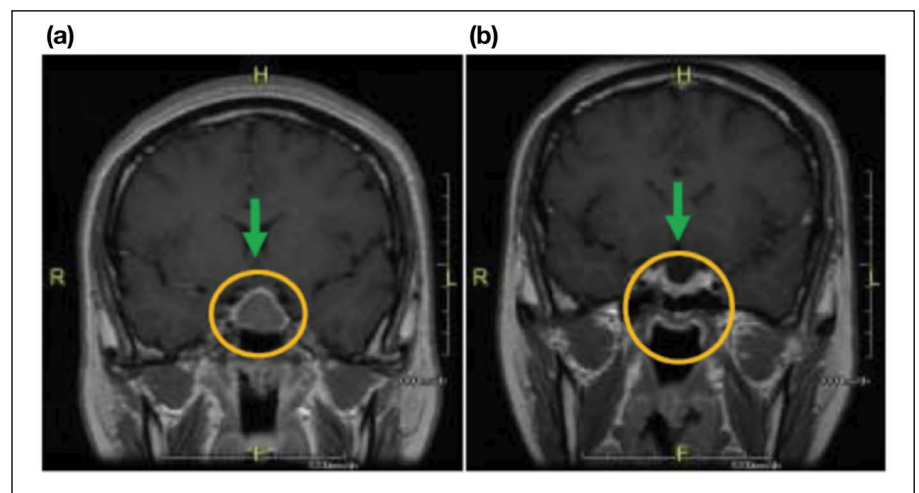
a: Preoperative MRI shows a non-enhancing oval sellar and suprasellar mass with compression of the normal pituitary tissue. b: Postoperatively, the large pituitary tumor was resected. There remained enhancing pituitary gland in the floor of the sella with expansion of the sella from the large macroadenoma, which has been removed.
